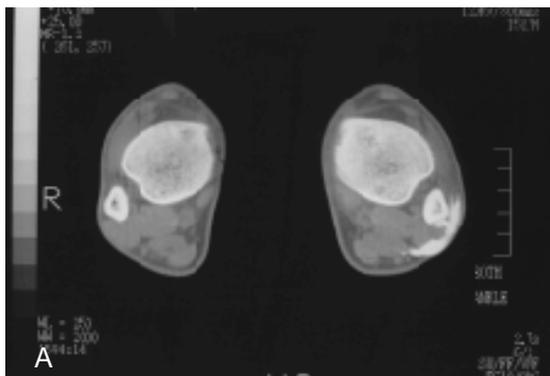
Computed tomogram with peroneal tenography of a 22-year-old male shows leakage of dye into anterolateral side due to superior peroneal retinacular injury without subluxation or dislocation of peroneal tendons in Lt. side.
